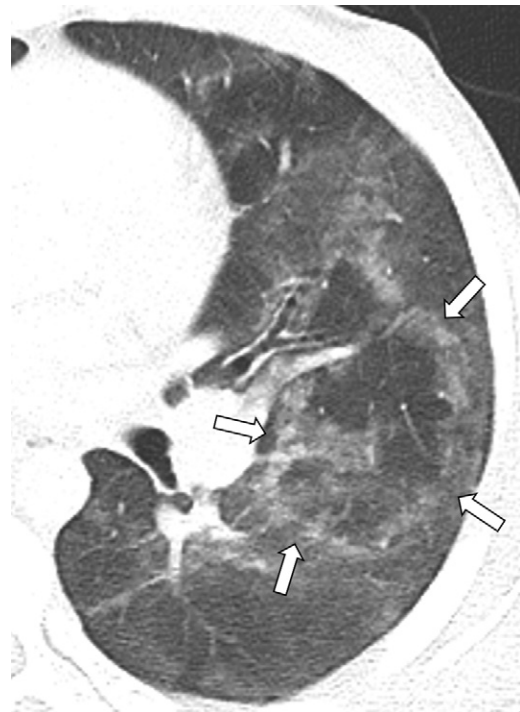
Image in a 17-year-old boy with history of electronic cigarette tetrahydrocannabinol use for 2 months presented with 8 days of nausea, vomiting, abdominal pain, and fever. Patient later developed shortness of breath and chest pain. Axial lung window (width, 1500; level, -700) image of CT with contrast enhancement performed 1 day after presentation demonstrates presence of central ground-glass opacity surrounded by complete ring of denser consolidation, also known as the reversed halo sign (atoll sign) (arrows).
